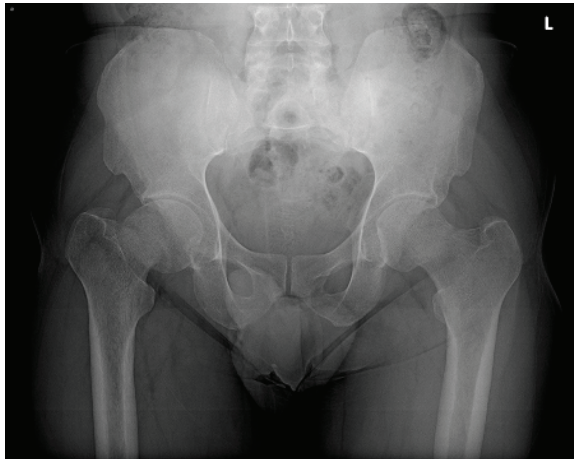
X-ray pelvis showing displaced fracture Neck of Femur bilaterally with generalised osteopenia
